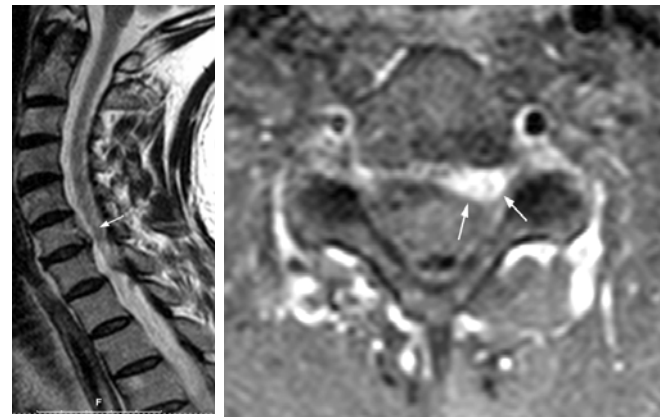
Left: Follow up T2-weighted sagittal image after 2 months shows prominent regression in the mass like appearance of the sequestered disc in the subarachnoid space (arrow). Right: Two months later follow up contrast enhanced T1-weighted axial image represents almost total resorption of the sequestered fragment (arrow).
